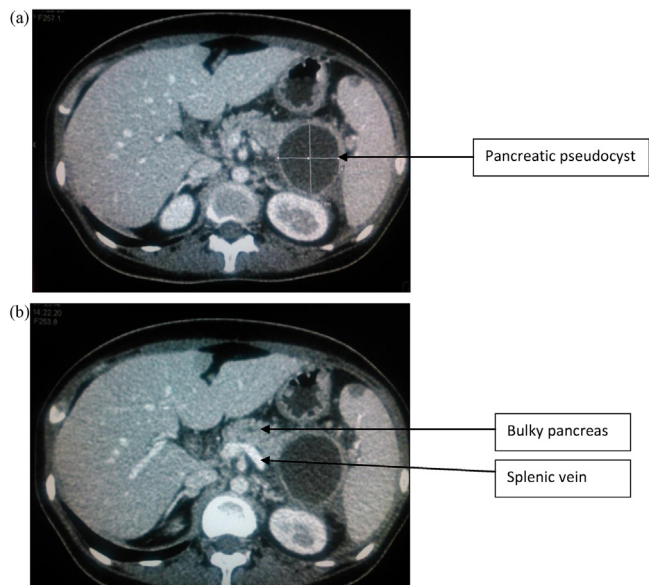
(a) CT scan section demonstrating the pseudocyst in the pancreas. (b) CT scan section demonstrating features of acute pancreatitis.
